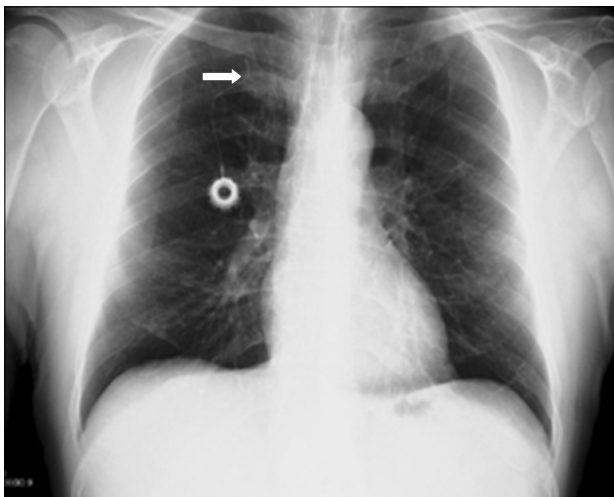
Pinch-off syndrome due to chronic compression between the clavicle and the first rib (X-ray imaging, arrow).
